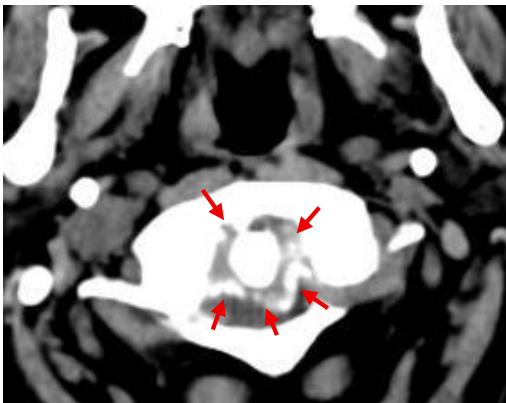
Case 3 (Retro-odontoid Pseudotumor) - Transverse cervical CT scan demonstrating calcification of the atlantoaxial ligament complex (arrows).
